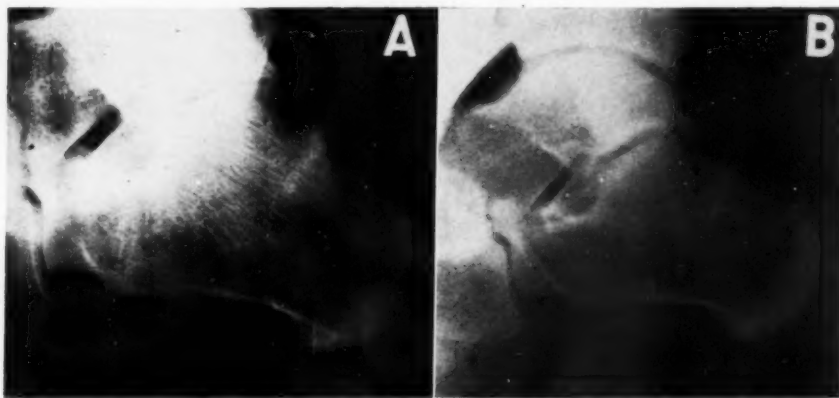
Case 3: A. Lateral roentgenogram of left calcaneus made on April 9, 1943, showing incomplete fracture, two weeks after onset of symptoms. B. Roentgenogram made on May 17, 1943, fifty-two days after onset. Note callus formation with partial obliteration of fracture line.
